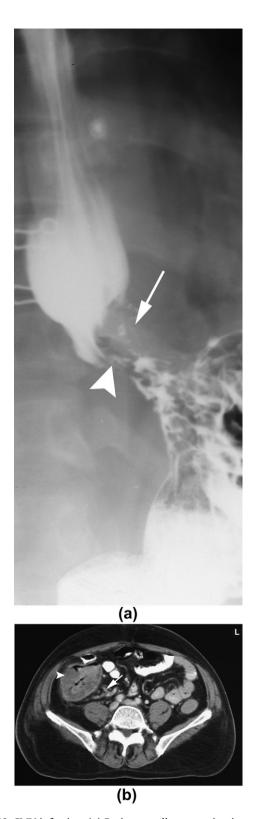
CMV infection. (a) Barium swallow examination shows an ulcer (arrow) in the distal oesophagus with surrounding plaque-like mound of oedema (arrowhead) (b). Axial CT image shows symmetrical thickening and submucosal oedema of the caecum (arrowhead) with engorged ileocolic blood vessels (arrow) in a patient with CMV ileocolitis.
